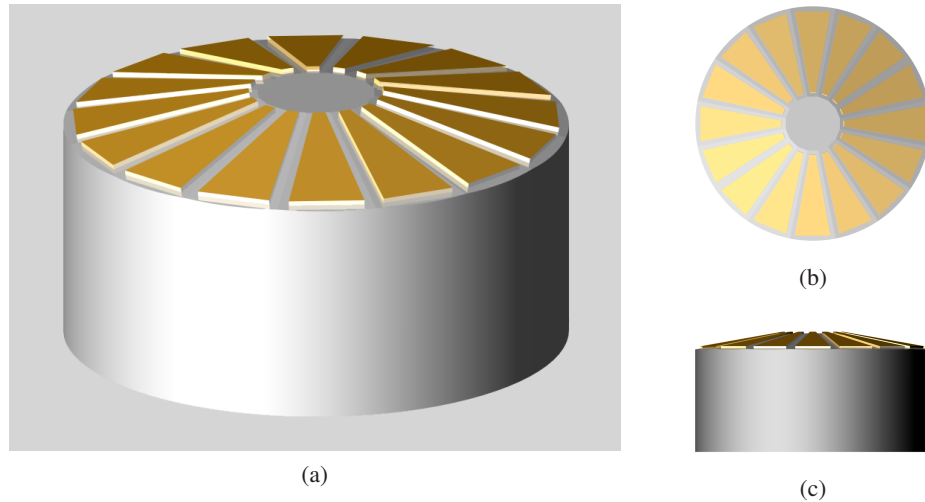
Final design and basic arrangement of the transducer elements within the ultrasound probe (rendered CAD depiction).
